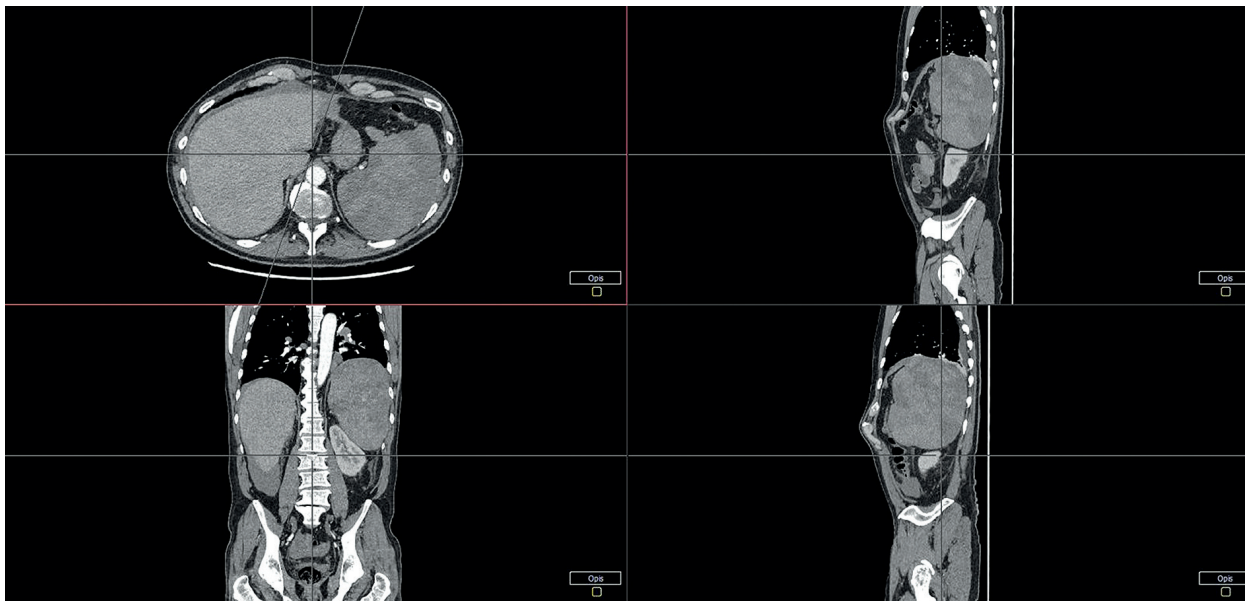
Computed tomography image, taken during emergency diagnostics in emergency room showing a significantly enlarged spleen suspected to be fractured and free fluid in the abdominal cavity with a density of blood
